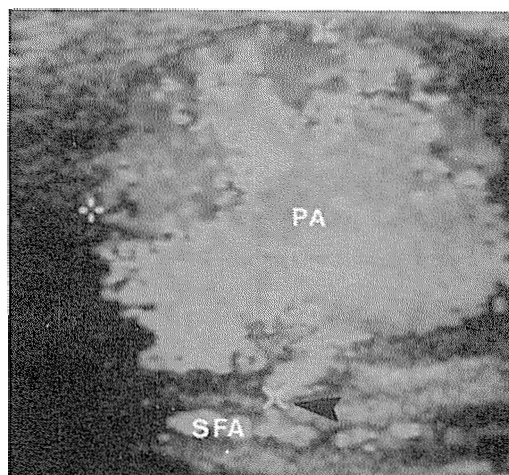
A longitudinal color and pulsed Doppler image of the pseudoaneurysm (PA) at the ventral aspect of the superficial femoral artery (SFA) showing the cavity communicating with the artery by a sinus tract (arrow), and characteristic "to and fro" waveform.
